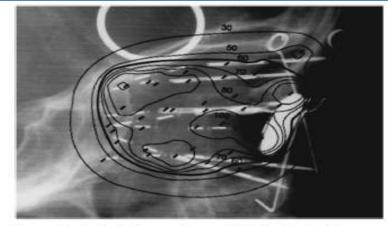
Lateral X-ray of an orbital implant with superimposed isodose lines. The bold 50 cGy/h covers the implant back to the apex of the orbit. Reprinted with permission from
